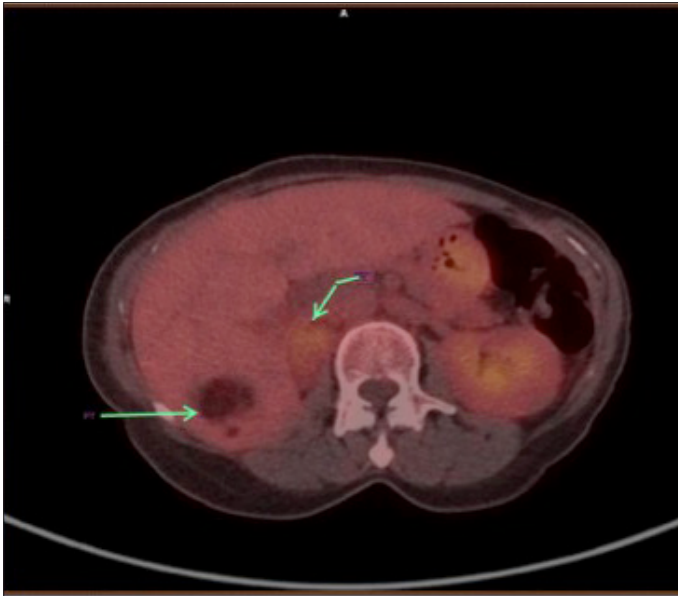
Axial view demonstrating reduced FDG uptake in the right renal fossa and increased necrosis in the liver lesion in July 2017 (green arrows)
